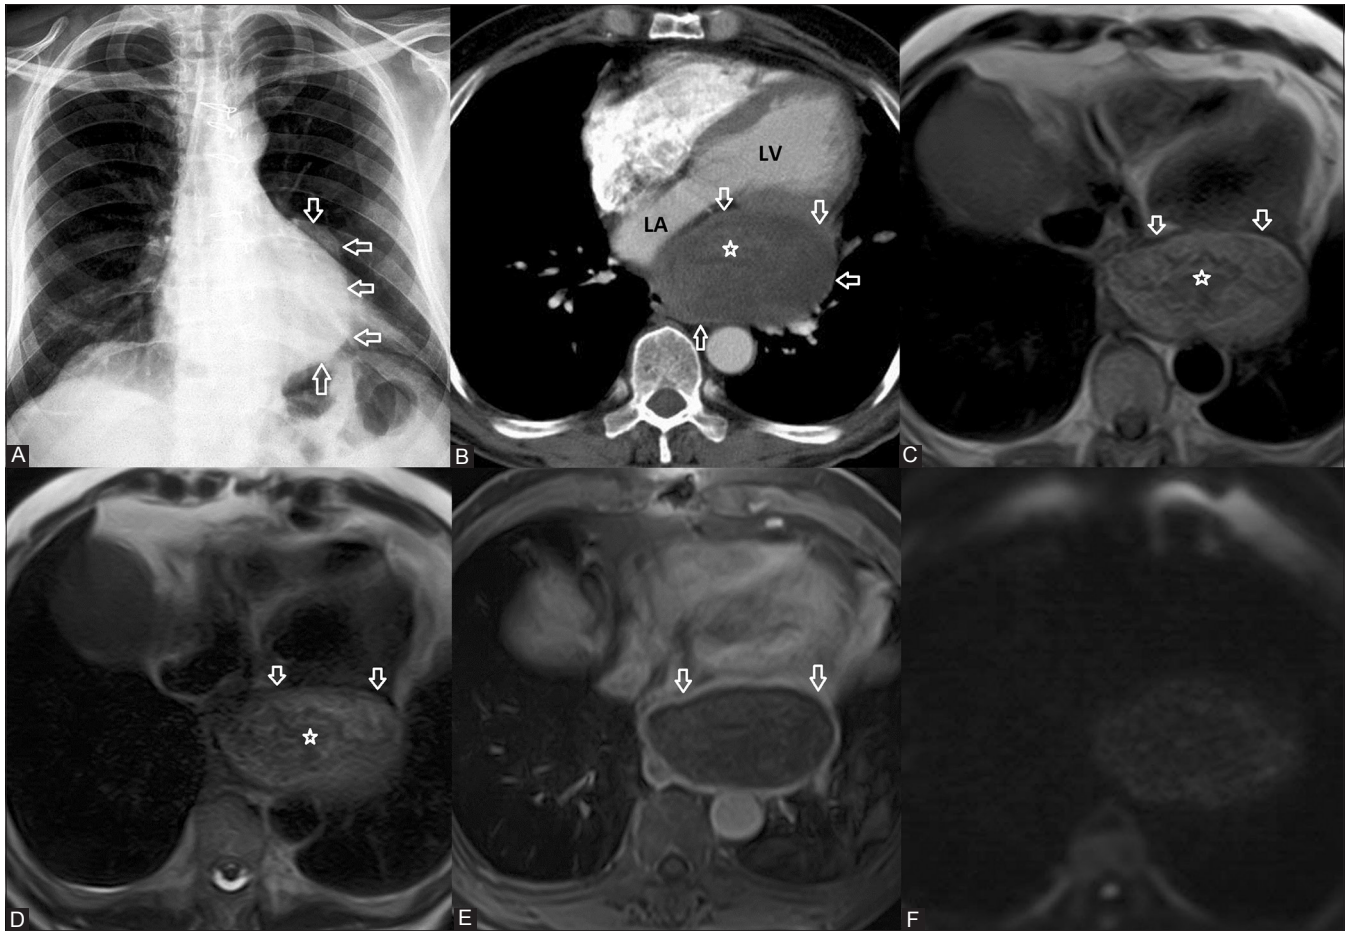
(A-F): Pericardial gossypiboma in a 54-year-old male patient. Posteroanterior chest radiograph (A) shows a mass on the left side of the heart (arrows). Contrast-enhanced chest CT (B) reveals sharply defined rounded mass with enhanced rim (arrows) and central high-density curvilinear stripes (asterisks) at the left atrioventricular groove, compressing the left atrium and left ventricle. Cardiac MRI demonstrates enhancing smooth capsula (arrows) which was hypointense on T1- and T2-weighted images (C–E) and whorled wavy hypointensities (asterisks) on T1- and T2-weighted images (C, D). Internal component did not have any contrast enhancement. Diffusion-weighted images showed no diffusion reduction excluding an abscess (F). LA, left atrium; LV, left ventricle
